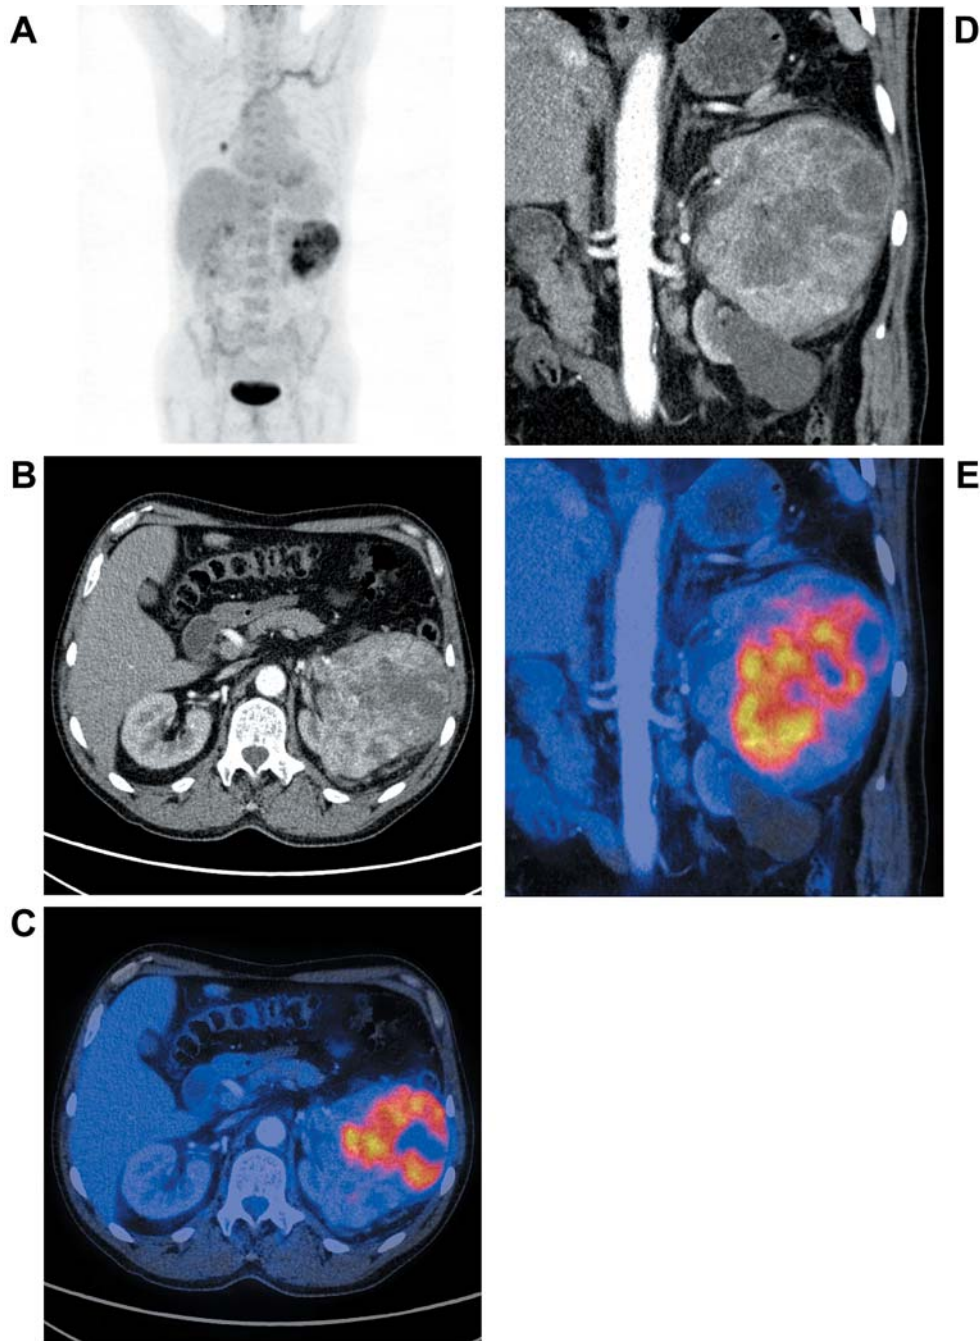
patient surviving more than 24 months after nephrectomy, after 12 months progression of hematogenous metastases, currently surviving under sunitinib therapy, conventional renal cell carcinoma poorly differentiated with increased level accumulation of FDG not exceeding  $SUV_{max}$  10. A – whole body MIP PET; B, D – CT images, C, E – PET/CT fusions – levels of displayed  $SUV_{max}$  0-10.*
